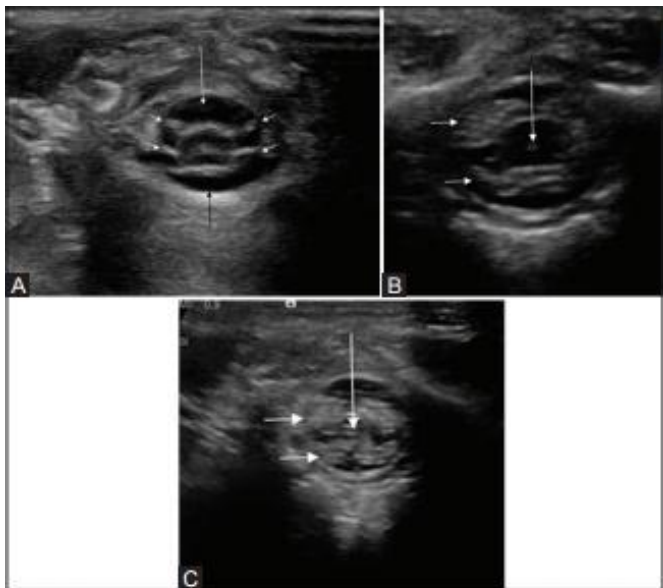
(A-C): (A-C) Normal sequential axial sonogram of thoracolumbar spine. The spinal cord appears hypoechoic, covered by an echogenic pial lining, and surrounded by anechoic CSF spaces. Note that the ventral (black arrow) and dorsal (white arrow) CSF spaces are nearly equal in dimension. The nerve roots appear echogenic (small arrows). On a more caudal section (B), there is normal enlargement of cord at conus medullaris, which tapers distally. Hence, a more caudal section would reveal only a bunch of nerve roots as echogenic structure (block arrows), with a central hypoechoic filum terminale (arrow in C)
